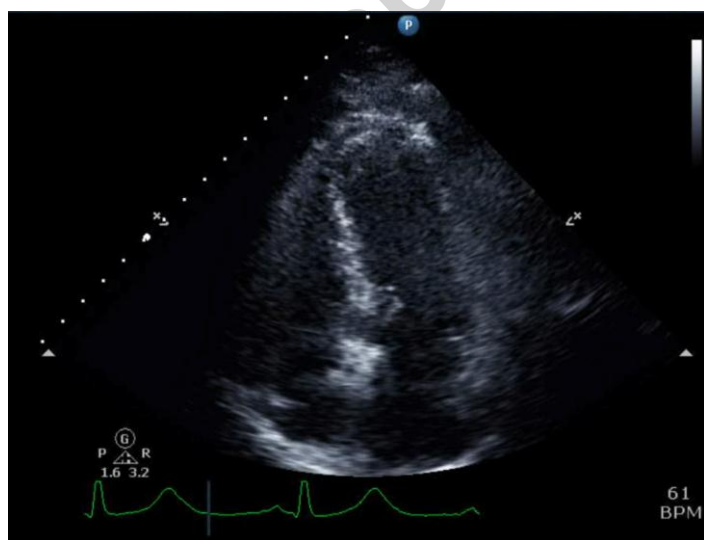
Still image of a four chamber view from the patient's echocardiogram demonstrating mild regional systolic dysfunction and hypokinesia of the mid-inferoseptal segment.
